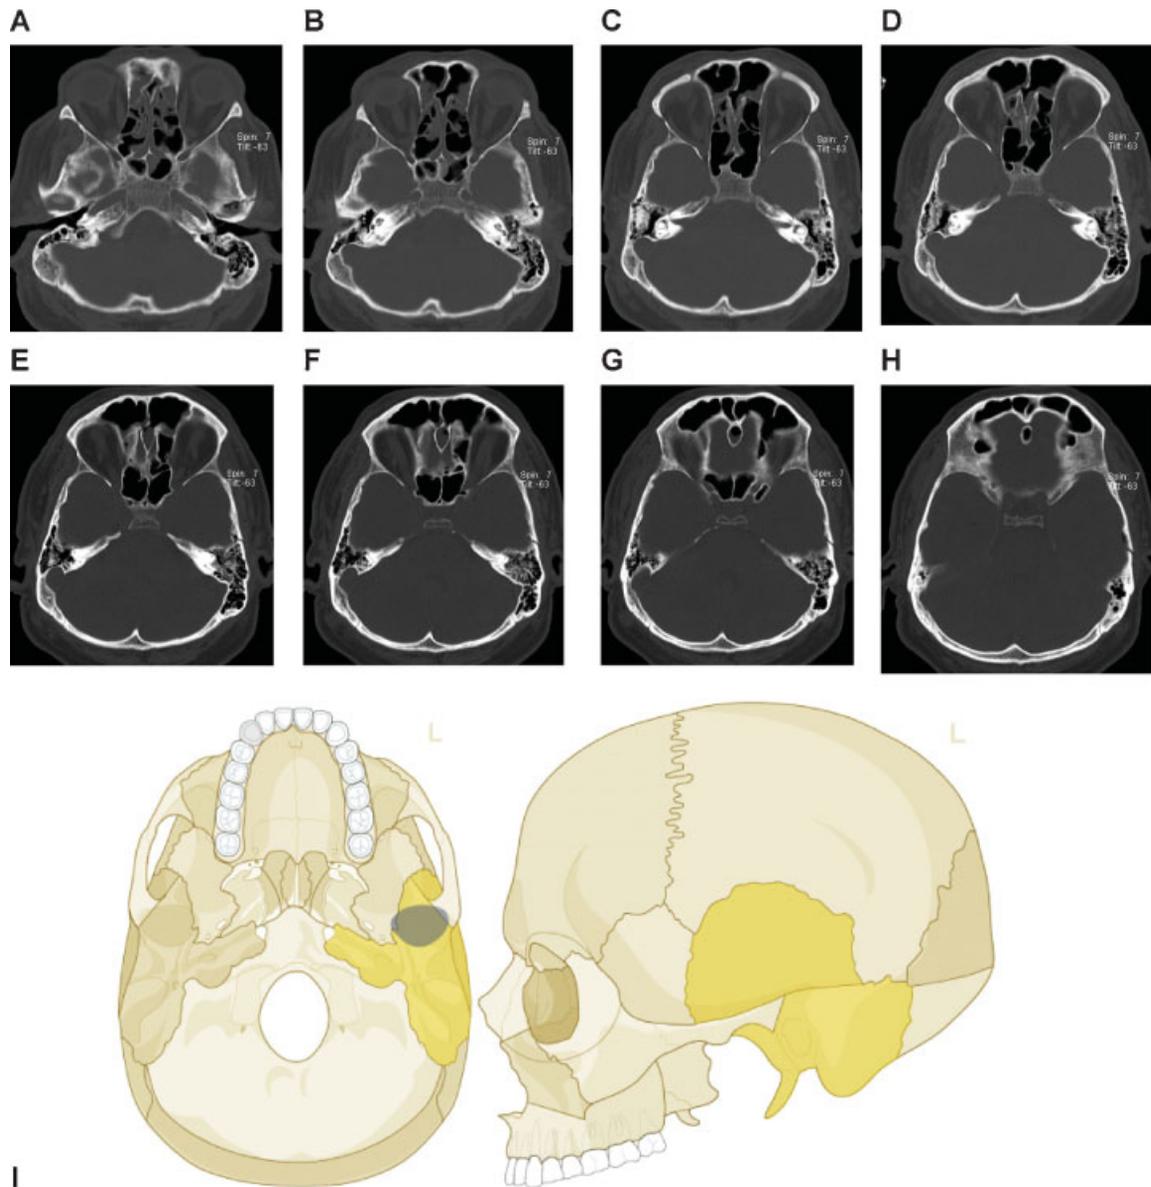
Single skull base fracture extending the temporal cranial vault. (A–C) Fracture through the skull base involving the left temporal bone, (D–I) traversing the glenoid fossa, and extending into the temporal cranial vault. The fracture is linear, unbranched and non-fragmented. Imaging: Computed tomographic axial views. (I) Level 3 code: 93 m.T0, 94 m.T0, This case example CMTR-93-94-002 is made available electronically for viewing using the AOCMIAC software at www.aocmf.org/classification.
